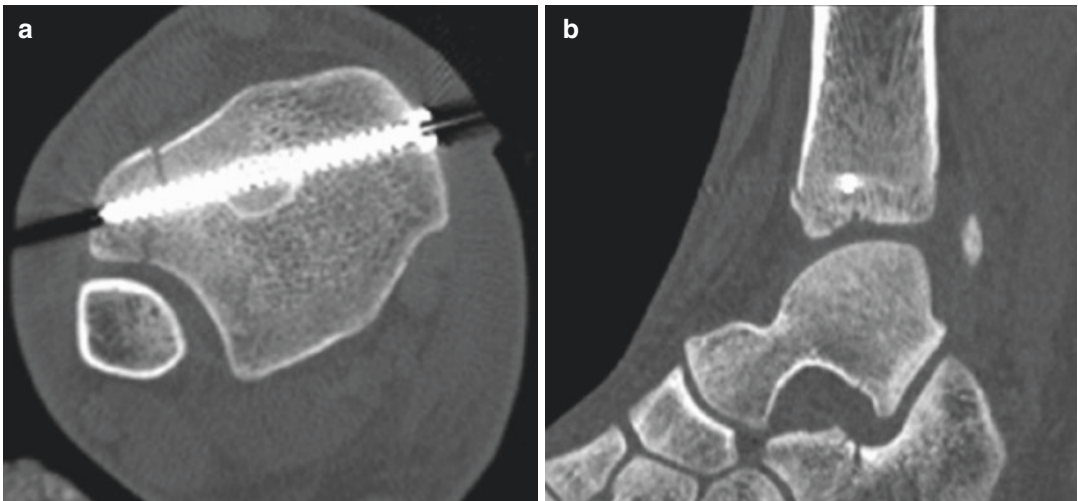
(a, b) Axial and reformatted sagittal computed tomography (CT) images of the fracture after surgery (Note the precise placement of the screw). (c, d)
